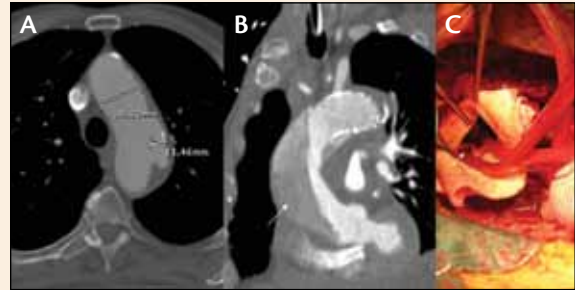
A case of RTAD. Preoperative CT angiography scan before TEVAR for a penetrating aortic ulcer of the distal arch (A). Postoperative maximum intensity projection CT angiography (B) showing the RTAD involving the ascending aorta (arrow). Intraoperative view (C) showing the proximal SINE at the proximal edge of the endograft on the outer curve of the distal arch (arrow).
